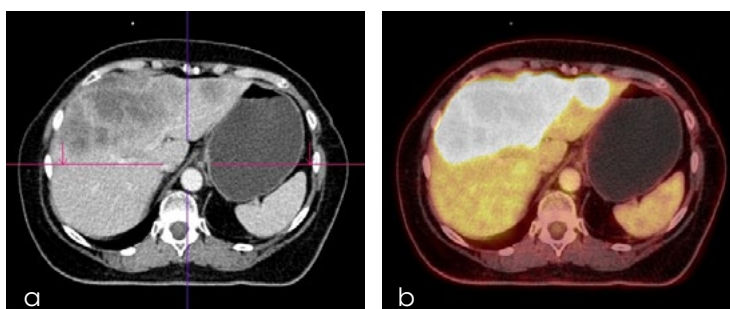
Contrast enhanced abdominal CT (a) and the PET/CT (b) before DSM-TACE show the extent and FDG uptake of the largest liver metastasis affecting both liver lobes (segments III, IV, V, VII and VIII)
